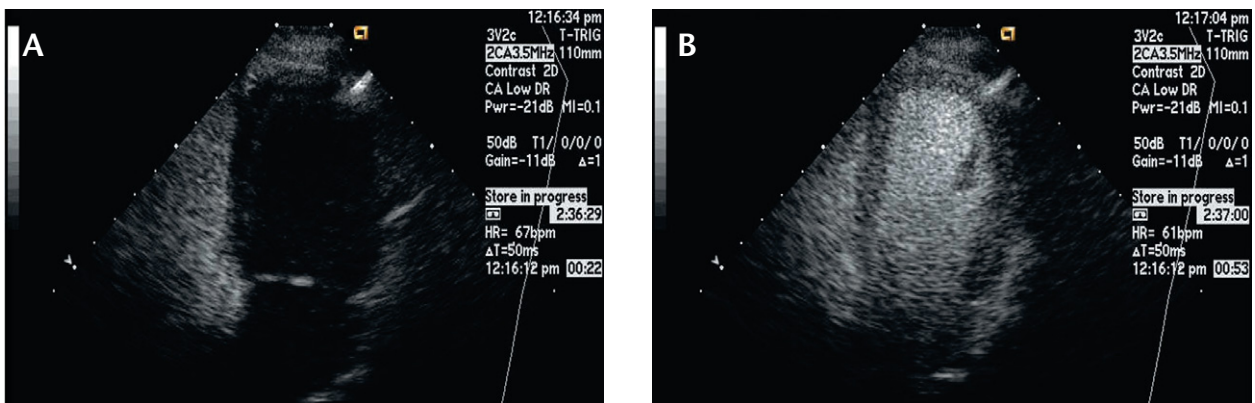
Ultrasound images of the left cardiac chambers (from www.acuson.com). (A) Before contrast agent entered the left cardiac chambers. (B) After contrast agent entered the left cardiac chambers: the arterial and ventricular lumens are well enhanced and the border of the ventricular myocardium is very well delineated.
